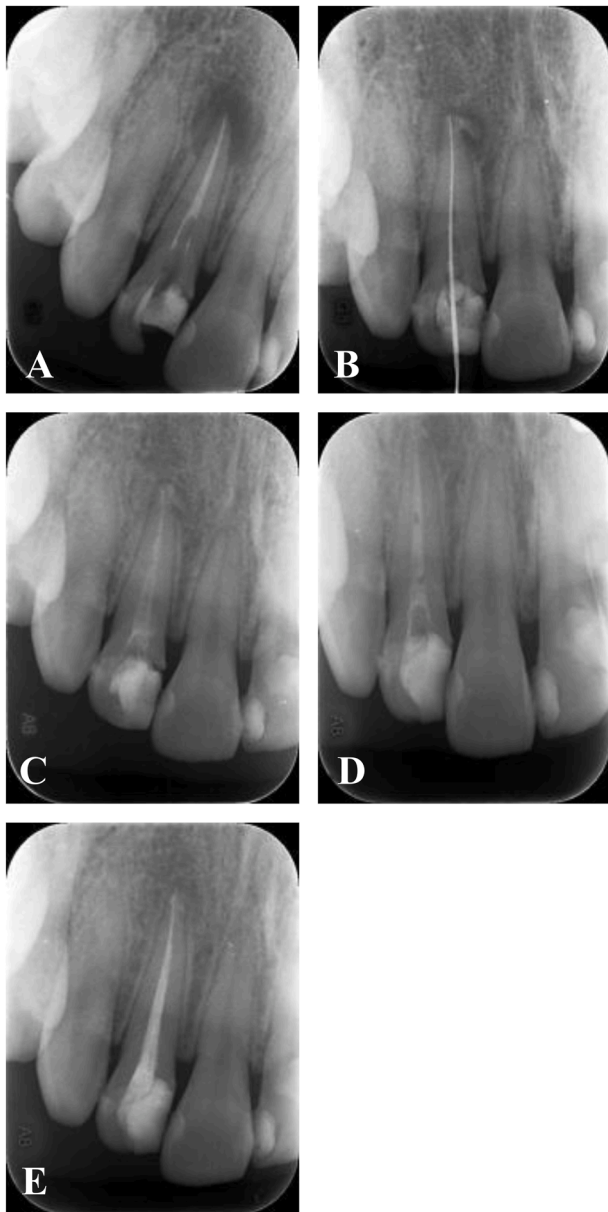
A series of periapical radiographs showing nonsurgical calcium hydroxide endodontic treatment of a right maxillary lateral incisor with a periapical radiolucent lesion, finally resulting in complete healing of the periapical lesion. (A) The initial periapical radiograph showed a restoration in the mesial crown portion and the filling materials in the root canal of the right maxillary lateral incisor. Moreover, a radiolucent lesion was noted at the periapical area of the right maxillary lateral incisor. (B) After 5 months of the root canal therapy with calcium hydroxide as the intra-canal medicament, the periapical radiograph revealed the evidence of partial healing of the periapical radiolucent lesion. (C) After 9 months of the root canal therapy with calcium hydroxide, the periapical radiograph demonstrated the persistent healing of the periapical radiolucent lesion. (D) After 24 months of the root canal therapy with calcium hydroxide, the periapical radiograph exhibited the nearly complete bone filling into the periapical radiolucent lesion. (E) After 26 months of the root canal therapy with calcium hydroxide, the root canal filling was
